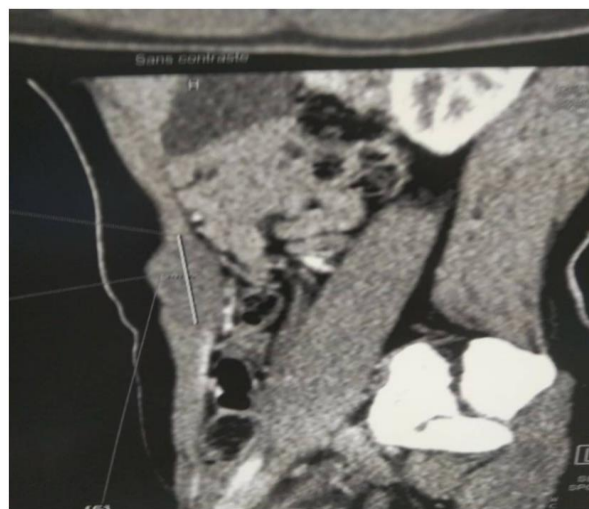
CT image of a sagittal section showing the location of the mass
